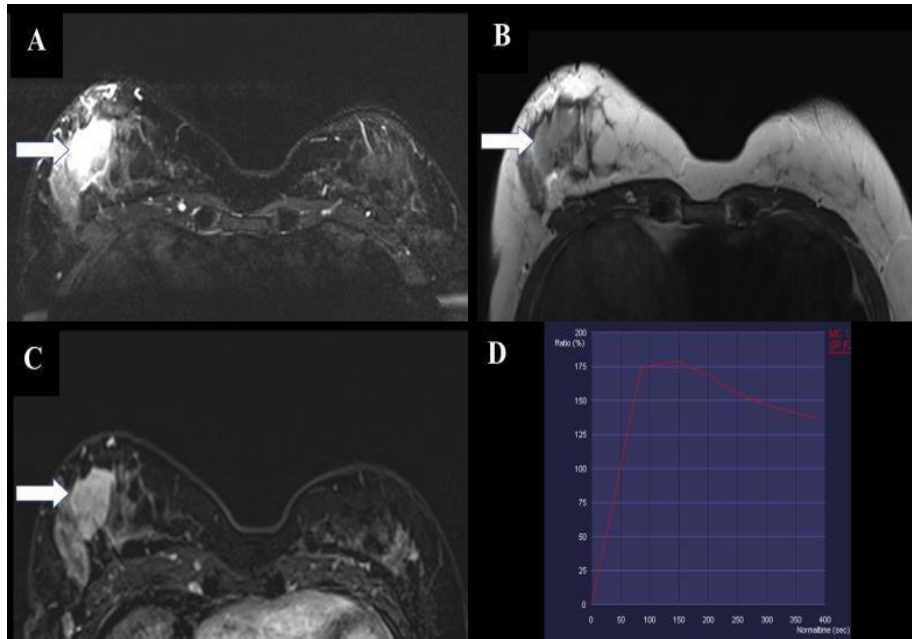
MRI features of invasive papillary carcinoma in a 44-year-old woman presenting with a right breast lump. (A) Axial STIR image shows TIRM hyperintensity. (B) Axial T2-weighted image demonstrates hypointensity of the lesion. (C) Subtracted dynamic contrast-enhanced image reveals a large irregular lesion with heterogeneous internal enhancement at the 6–8 o'clock position (white arrow). (D) Kinetic curve shows a type 3 (washout) enhancement pattern.
